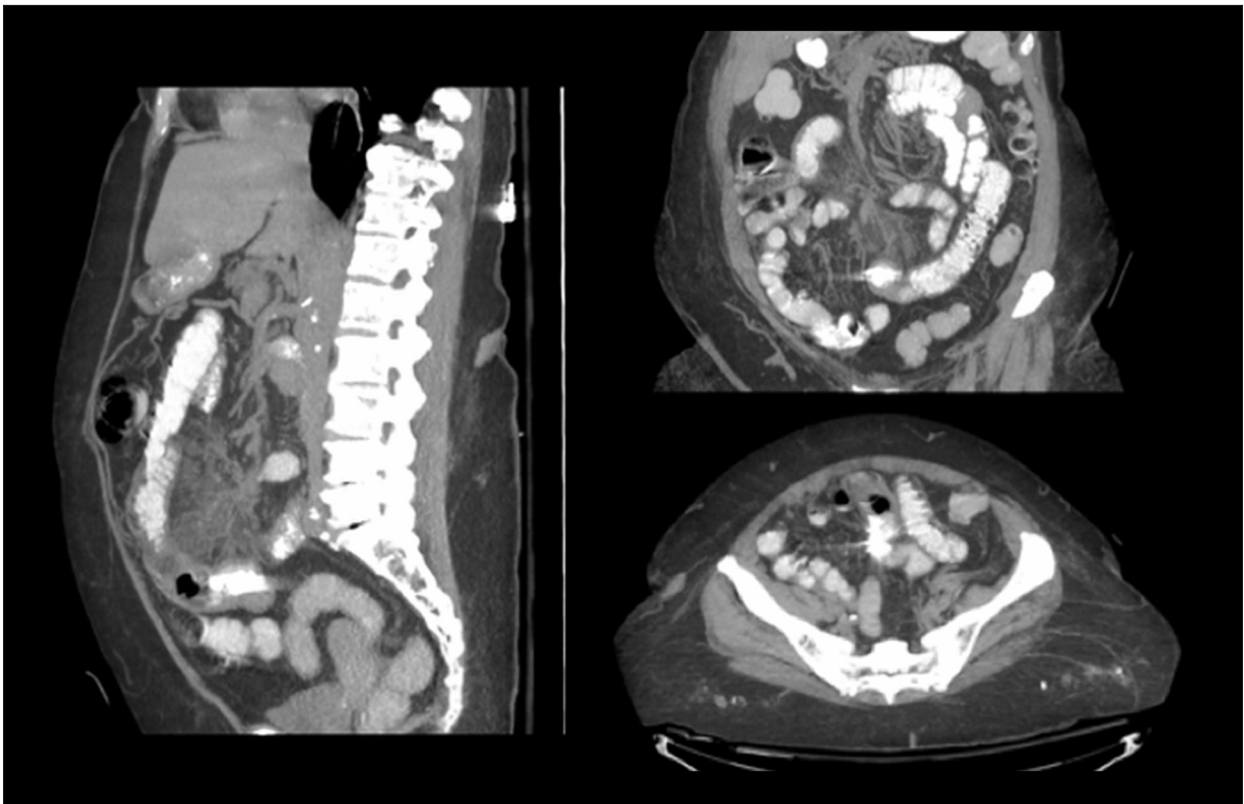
Multi-planar reconstruction computed tomography shows the endoscopic capsule in the lower abdomen, causing small bowel obstruction.
